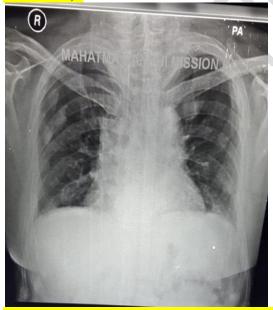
Chest X-ray showing opacities on right upper lobe.
